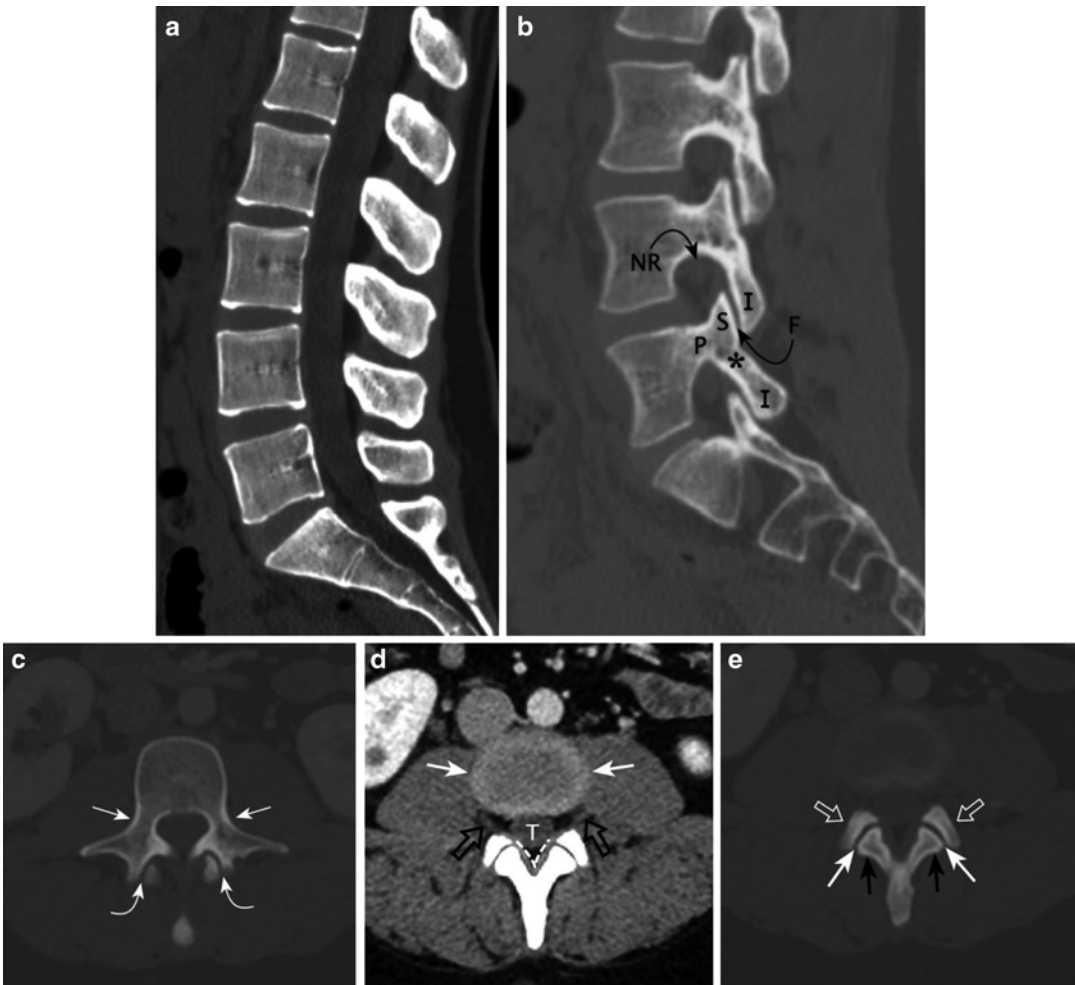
Normal CT of lumbosacral spine. (a) Midline sagittal reformatted CT demonstrates normal alignment of the vertebral bodies and spinous processes. (b) Sagittal reformatted slice through left neural foramina (lateral to midline) demonstrates the superior articular facet (S), inferior articular facet (I), facet joint (F), pedicle (P), pars interarticularis (*), and nerve root (NR). (c) Axial slice through L2 demonstrates the pedicles (straight arrows) and inferior aspects of the L1–2 facet joints (curved
